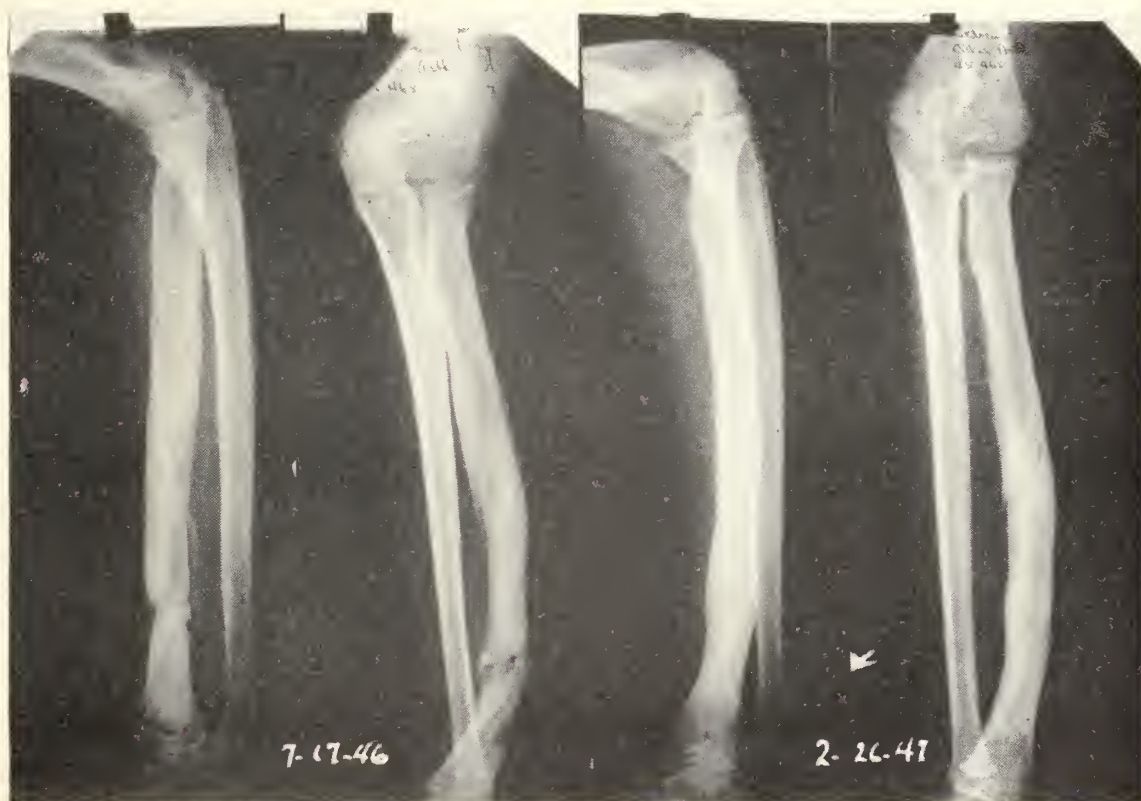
Case 1. Roentgenograms, July 17, 1946, and February 26, 1947. Non-operative treatment of acute hematogenous osteomyelitis: Preliminary report. John J. Killefer, M.D., and Robert C. Robertson, M.D.
